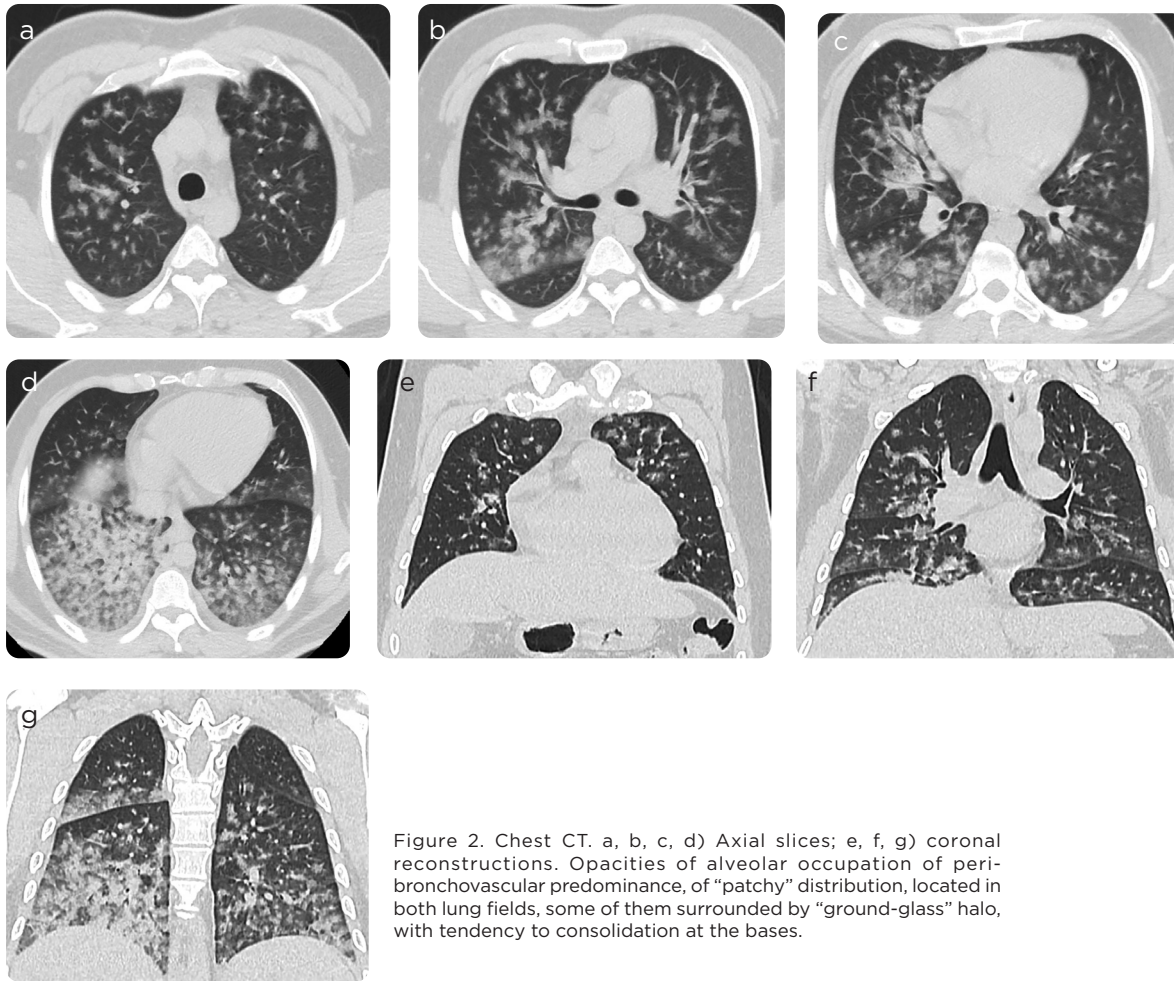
Chest CT. a, b, c, d) Axial slices; e, f, g) coronal reconstructions. Opacities of alveolar occupation of peribronchovascular predominance, of “patchy” distribution, located in both lung fields, some of them surrounded by “ground-glass” halo, with tendency to consolidation at the bases.
